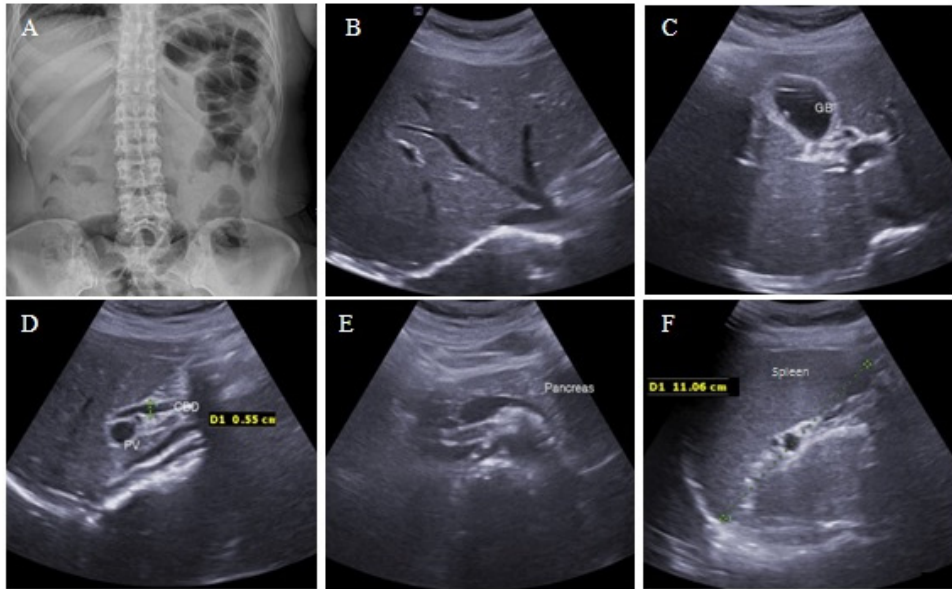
X-ray examination and Ultrasonography for abdomen.
